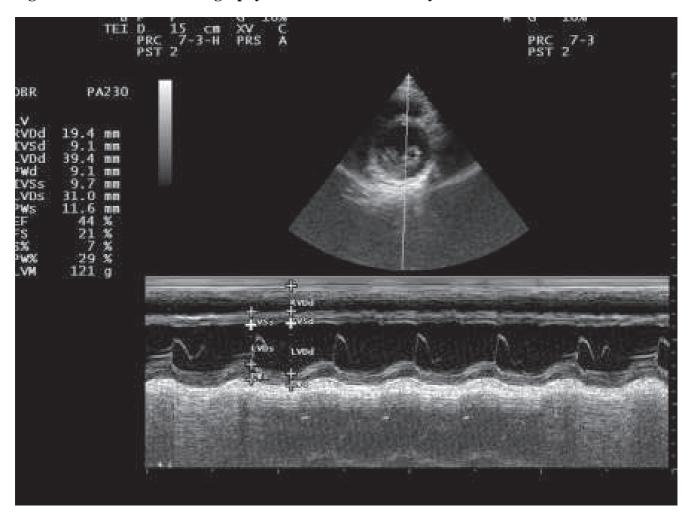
M mode echocardiography with assessment of LV systolic function.
